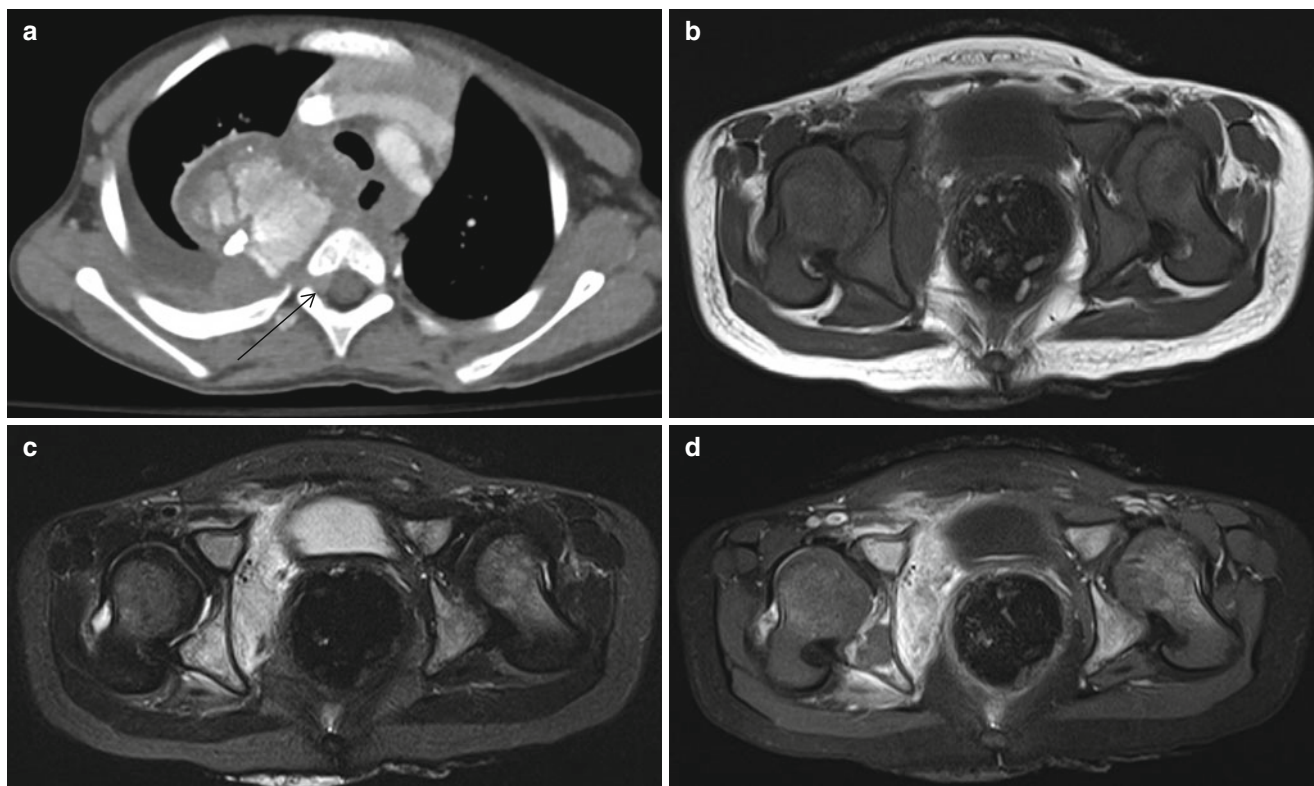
Mediastinal neuroblastoma with bone metastasis.* (a) Chest CT shows a large calcified mass in the posterior mediastinum extending through the right side neural foramen of the thoracic spine (arrow). Right pleural effusion is associated. (b–d) T1-weighted axial (b), T2 STIR axial (c), and postcontrast fat-suppressed T1 axial (d)
